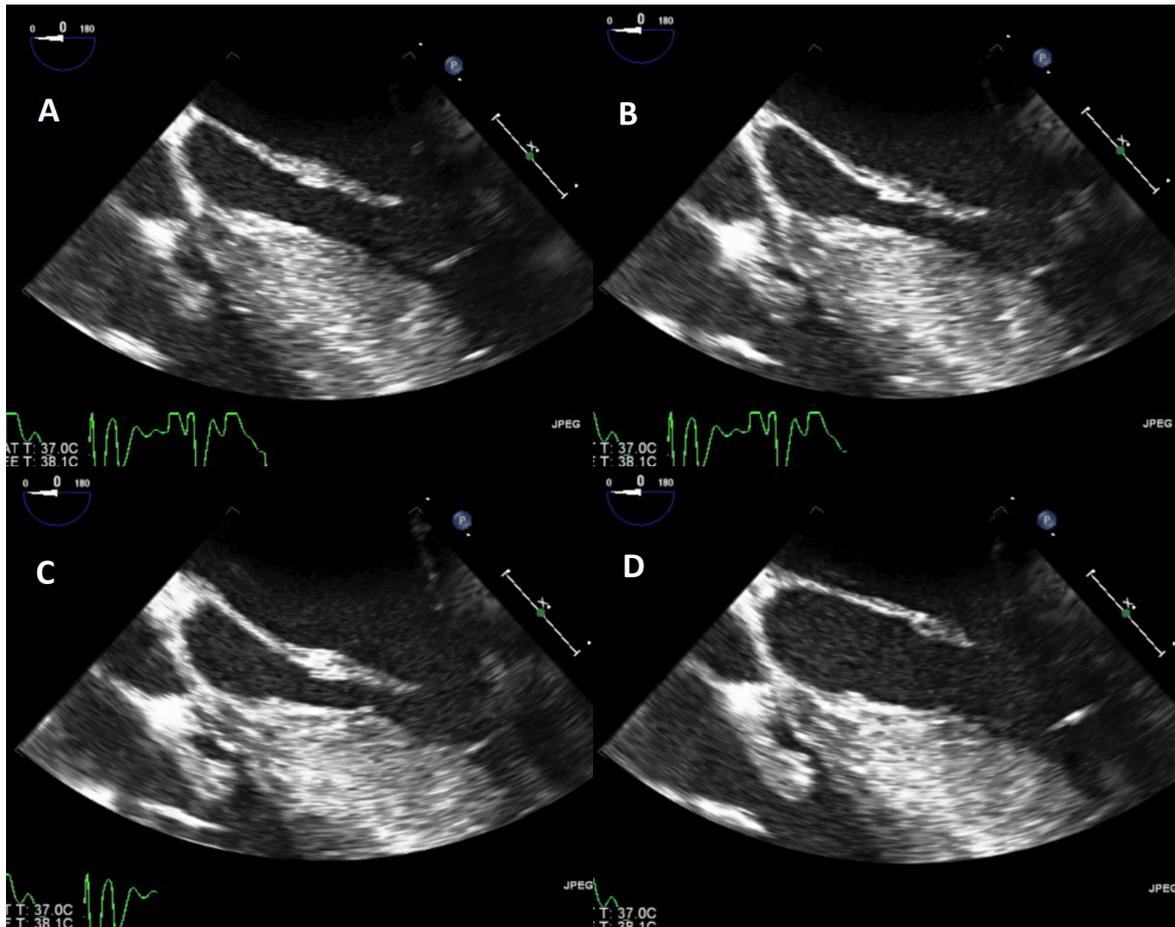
(A–D) Transesophageal echocardiogram at mid-esophagus showing different still-frame images of vegetation attached to device lead just above the level of the tricuspid valve. (A) Still-frame image of vegetation on tricuspid valve. (B) Still-frame image of vegetation on tricuspid valve at zero degree. (C) TEE image of vegetation on tricuspid valve. At 29 degree (D) TEE image of vegetation at 75 degree.
